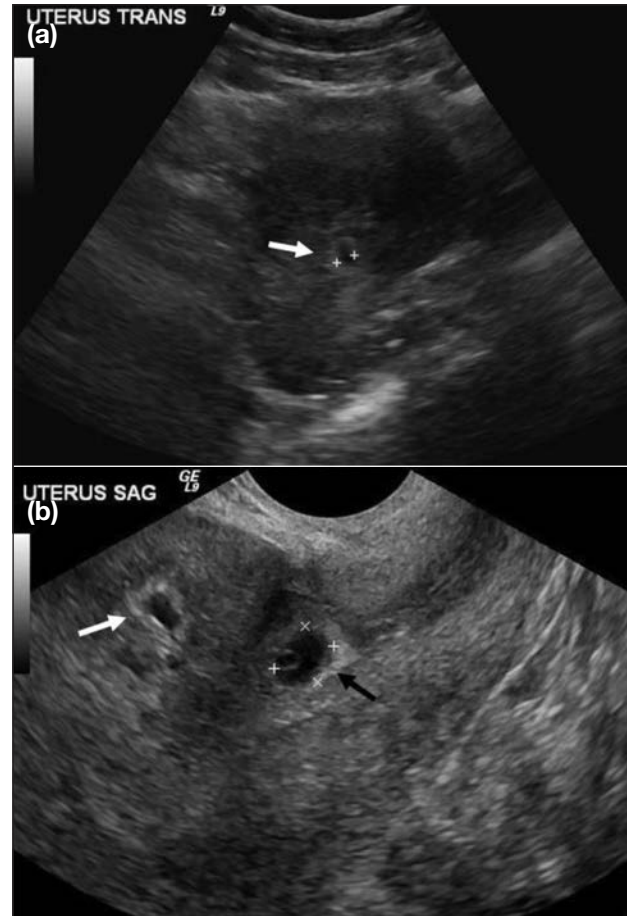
Transvaginal B-mode ultrasonographic images of a patient with Caesarean scar pregnancy showing heterogeneously echogenic intrauterine fluid.
